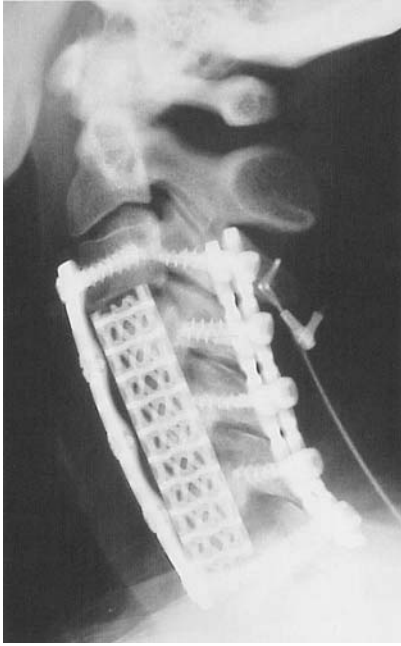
Postoperative lateral radiograph of multilevel anterior posterior decompression and reconstruction with titanium interbody cage, anterior plate and lateral mass reconstruction.
